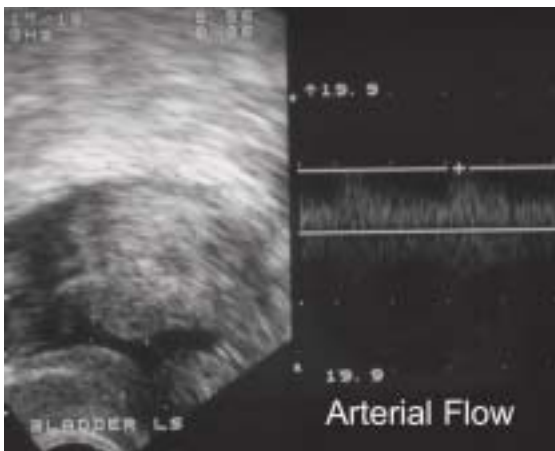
Transrectal Doppler ultrasound showing arterial flow pattern within the tumour.
